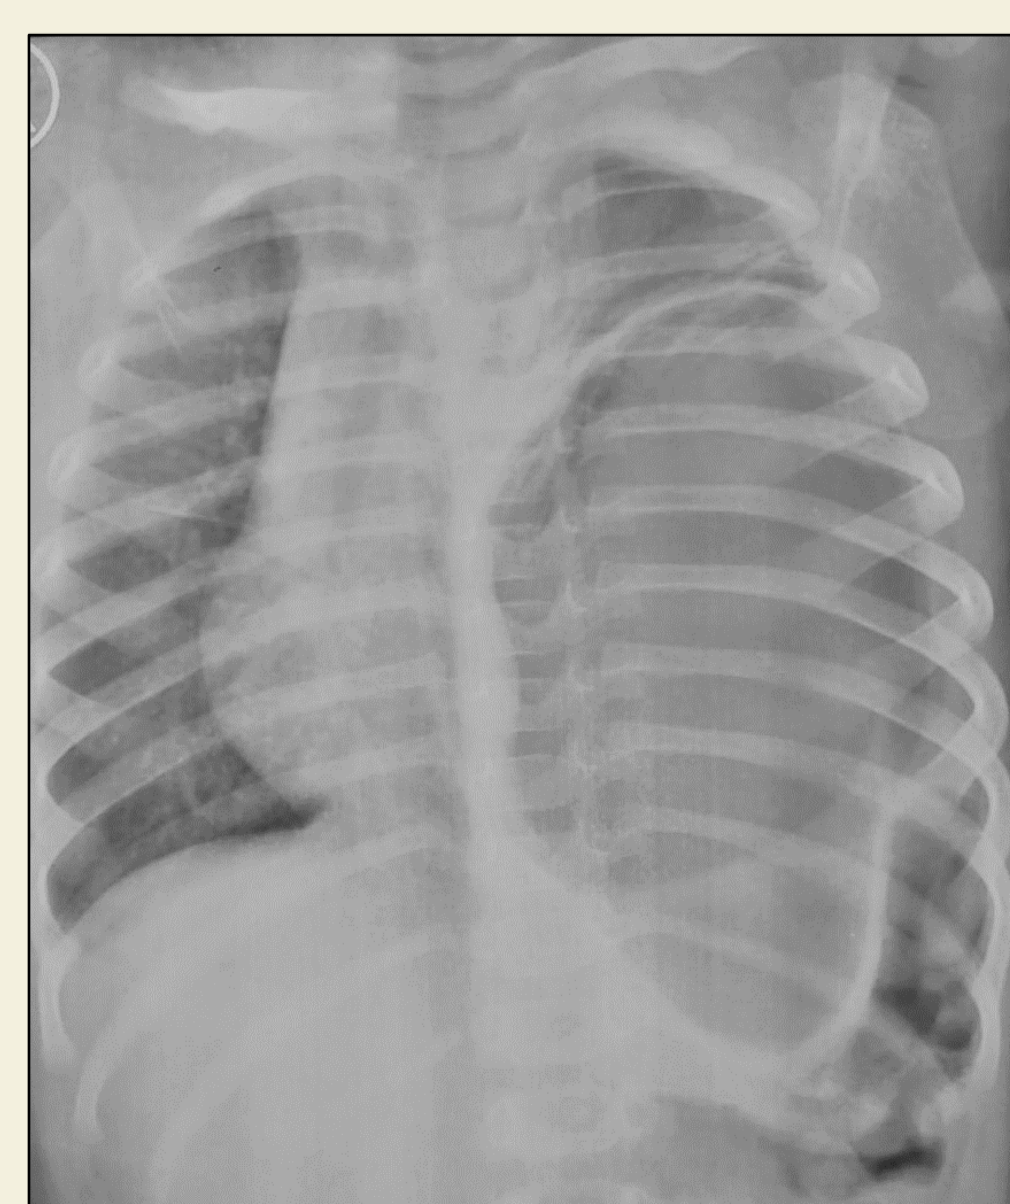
Chest x-ray at presentation suggestive of left diaphragmatic hernia
